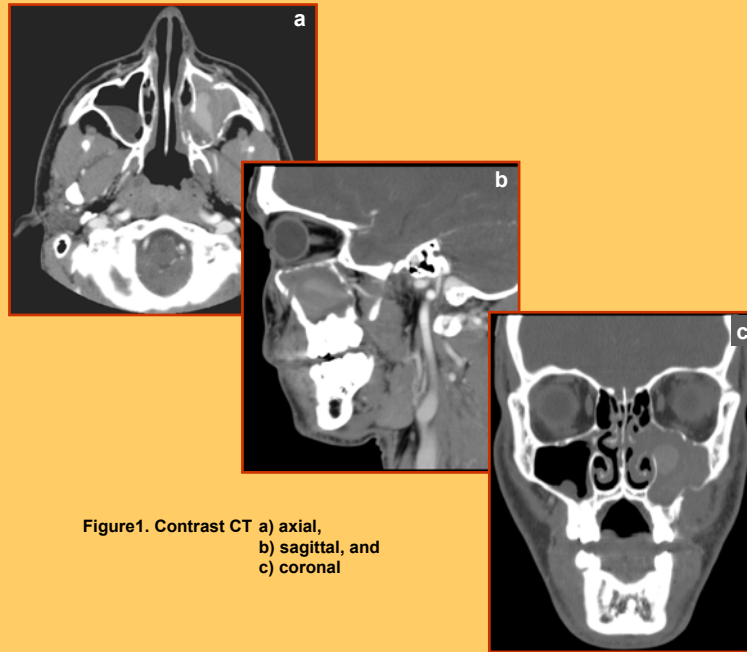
Contrast CT a) axial, b) sagittal, and c) coronal
